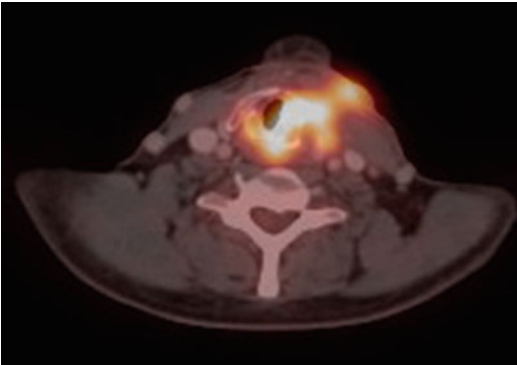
PET/CT fusion axial image showing an enhancing lesion involving hypopharynx with gross exolaryngeal extension
